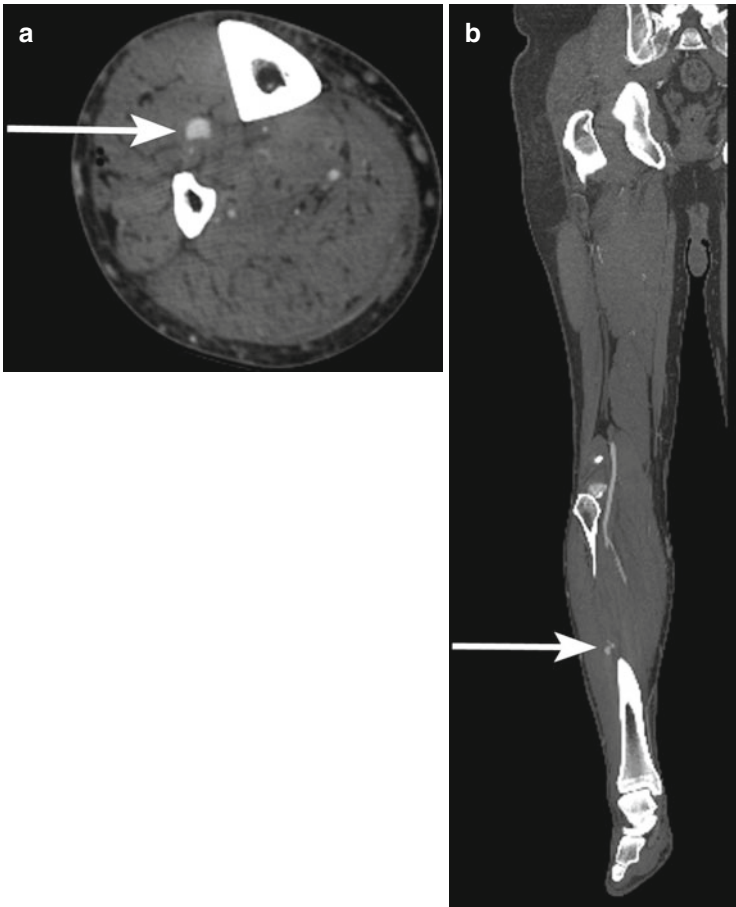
A young patient suffered a gunshot wound to the leg. Axial (a) and coronal (b) images from a computed tomography angiogram reveal extravasation of contrast (*arrows*) from the anterior tibial artery
